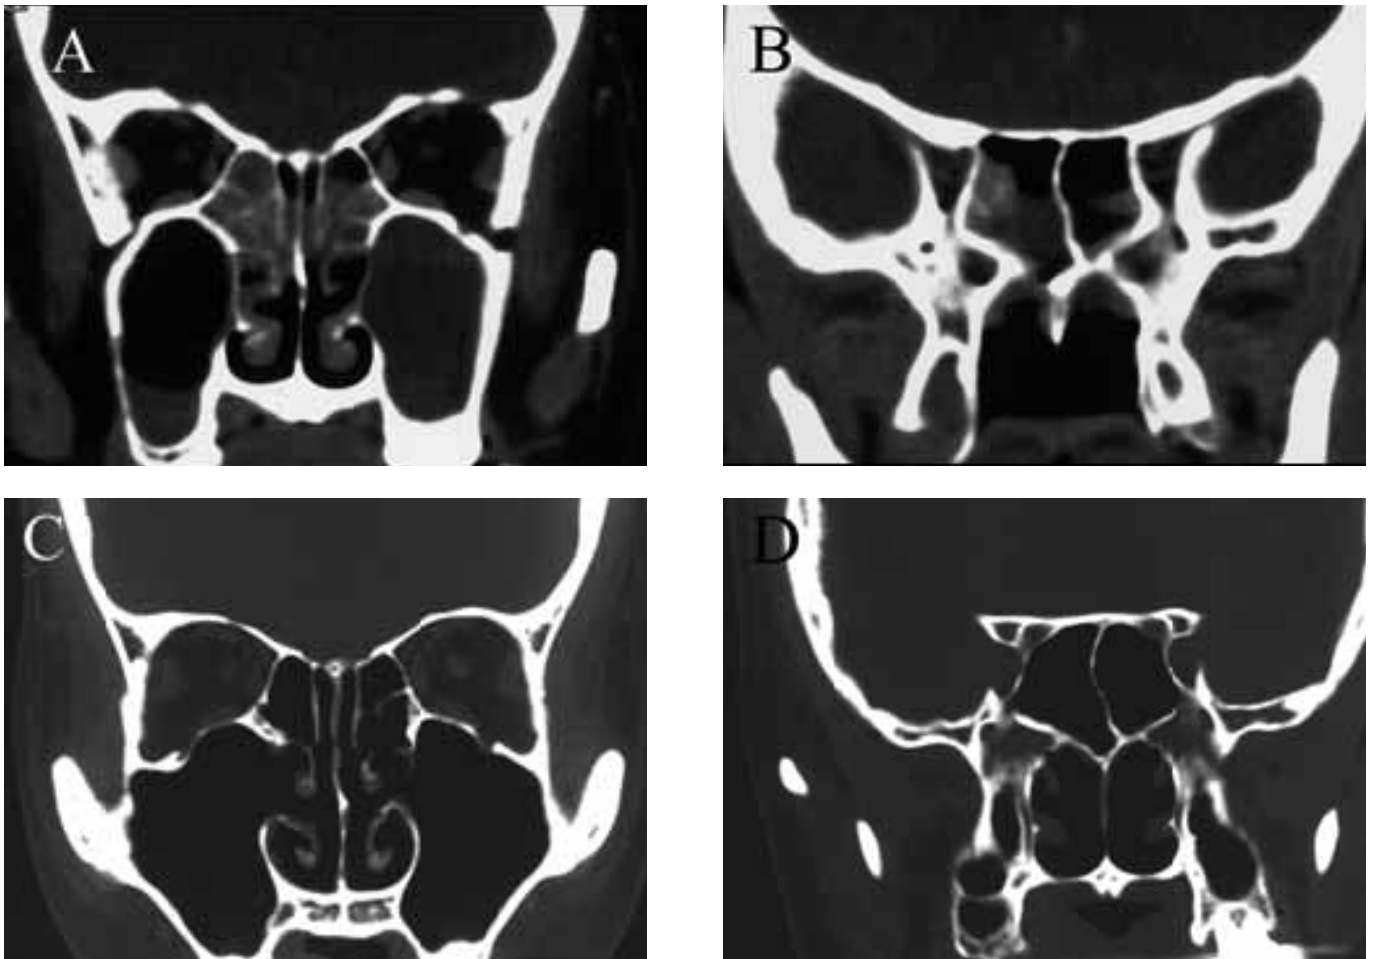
Coronal sinus CT before and following treatment A: Opacification of bilateral ethmoid and maxillary sinuses (Lt: complete, Rt: mild); before treatment B: Opacified sphenoid sinuses before treatment C and D: CT after endoscopic sinus surgery and anti-fungal treatment.
